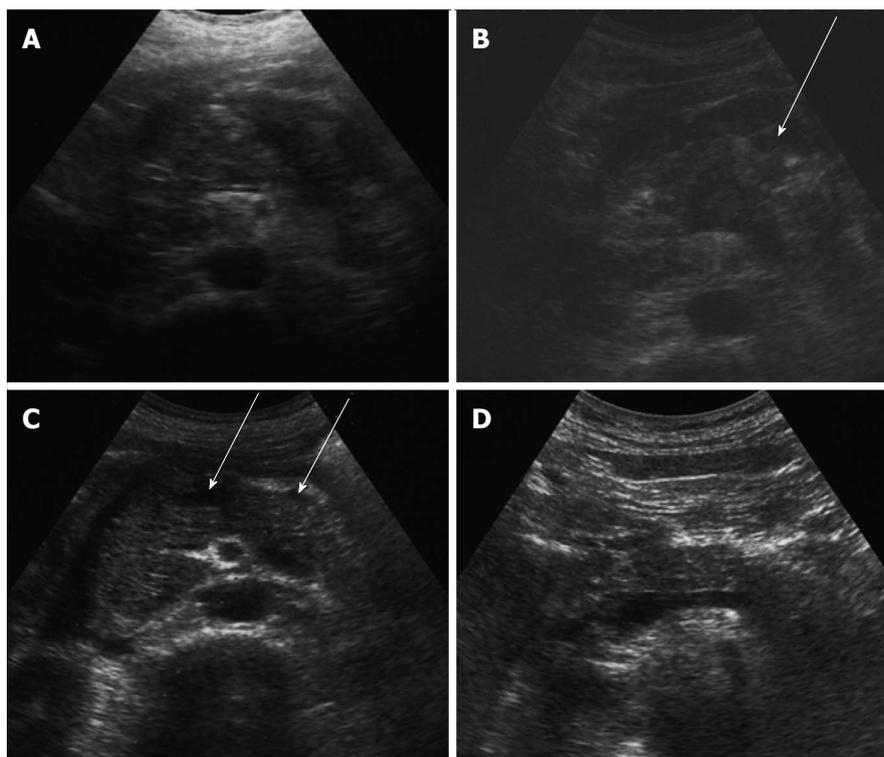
Ultrasound appearance of infected pancreatic necrosis before and after the treatment of acute pancreatitis. A: Infected pancreatic necrosis (IPN) involved the entire pancreas in the beginning of the disease; B: Liquefied areas in the IPN marked by arrows; C: Small necroses and liquid collections around the pancreas 2 mo after the beginning of treatment marked by arrows; D: Normal appearance of the pancreas 6 mo after the beginning of treatment.
